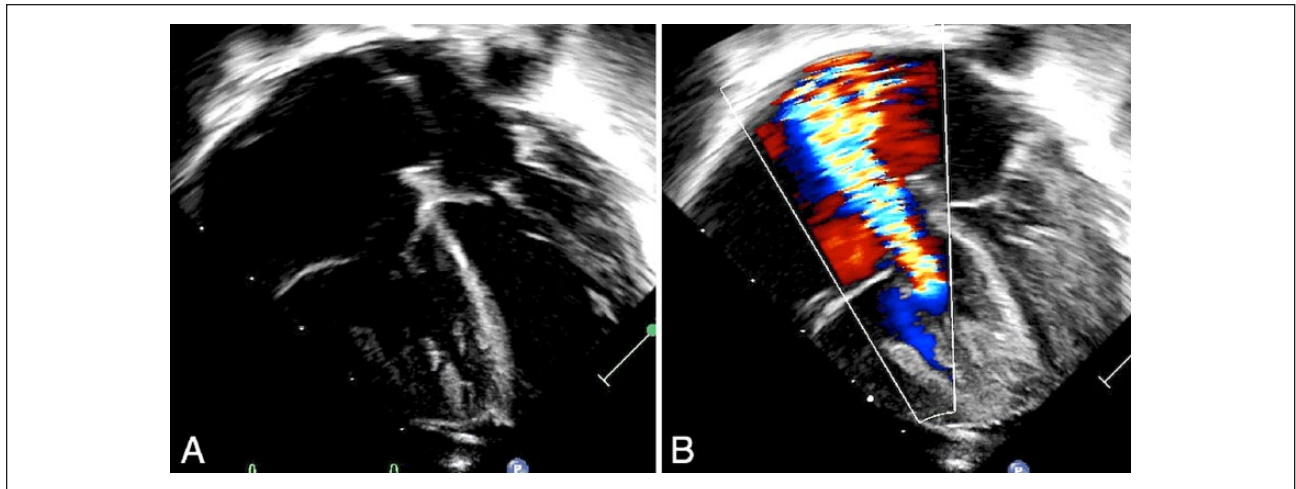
(A) Apical 4-chamber echocardiographic view in an infant with pulmonary atresia and intact ventricular septum demonstrates a dilated right atrium, with normal-sized tricuspid valve and right ventricle with mild right ventricular hypertrophy. There is poor coaptation of the tricuspid valve. (B) Color Doppler demonstrates moderate tricuspid regurgitation.
